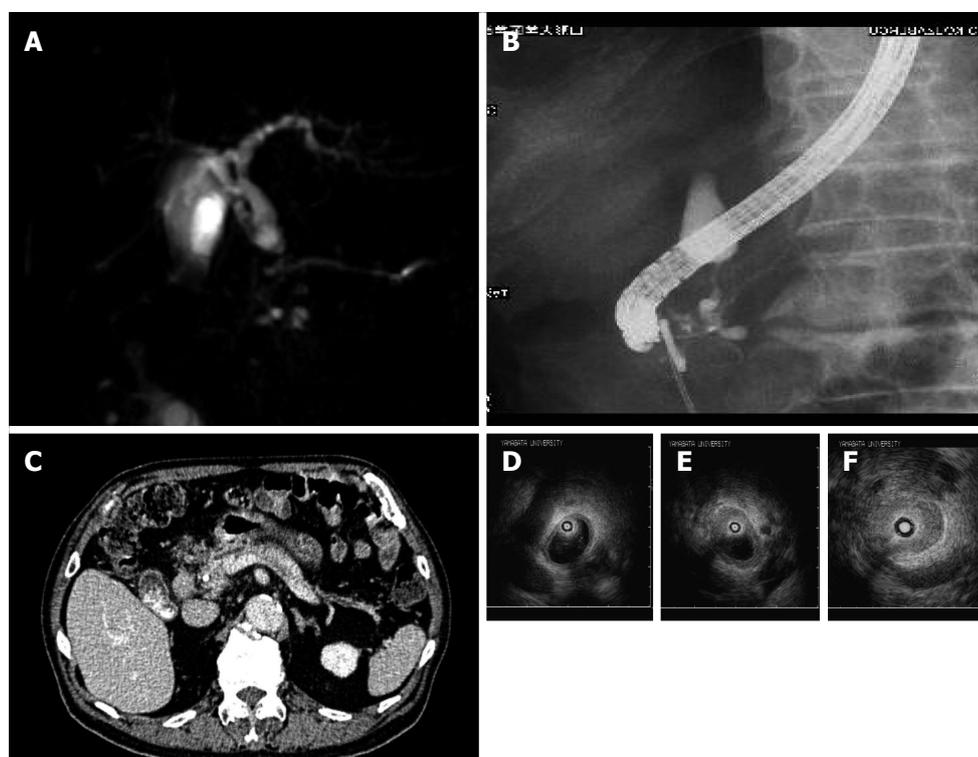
Imaging findings of Case 5. A, B: Stenosis in the lower extrahepatic bile duct and a slight dilation of the main pancreatic duct on endoscopic retrograde cholangiopancreatography (A) and magnetic resonance cholangiopancreatography (B); C: Normal size of the pancreas on abdominal computed tomography; D (at the hilar hepatic lesion); E (at the bifurcation of cystic duct); F (at the intrapancreatic lesion): Bile duct wall thickening with smooth inner and outer margin in areas with stenosis (F) and without (D, E) on intraductal ultrasonography.
